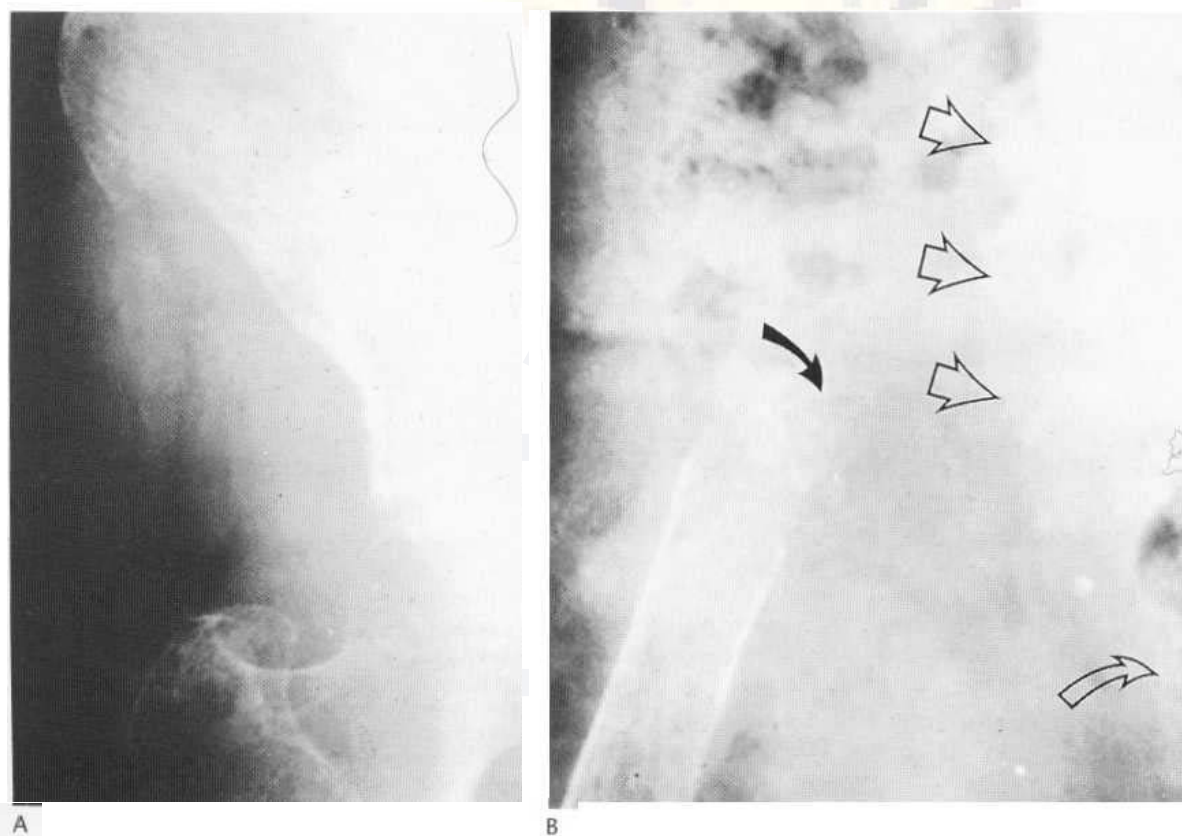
Vanishing bone disease. A 70-year-old woman presented with poorly localised pain in her right hip. (A) A radiograph at presentation reveals ill-defined destruction at the anterior inferior iliac spine. (B) Nine months later there is total destruction of the whole of the hemipelvis and hip joint. Note the faint outline of the residual femoral head (curved arrow), pathological fracture of the femoral neck and the articular surfaces of the sacrum and symphysis pubis which no longer articulate with bone (open arrows).
